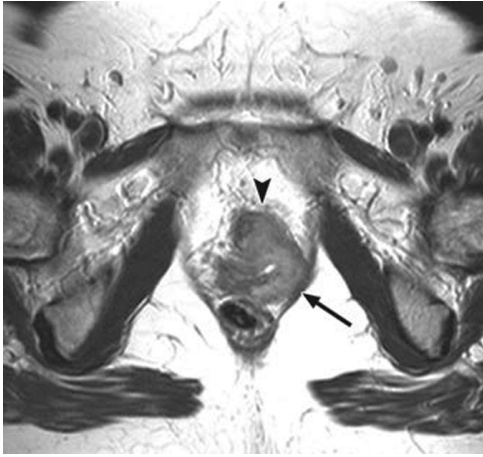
56-year-old woman with newly diagnosed vaginal carcinoma (cT4aN0M0). Symptoms include vaginal blood spotting with dyspareunia and dysuria. Axial T2-weighted 1.5-T image with pelvic coil shows vaginal carcinoma on left with extension to puborectal muscle (arrow) and tumor invasion of urethra (arrowhead).
